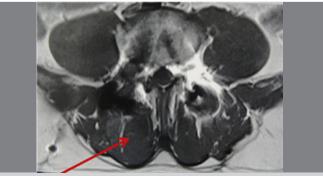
MRI image of 12 months postoperative showing broad muscle preservation (see arrow).
